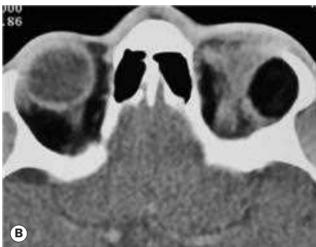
Orbital dermoid cysts – imaging. (A) Axial CT image showing a well-circumscribed heterogeneous superficial lesion; (B) deep dermoid – CT showing a well-circumscribed cystic lesion and bone remodelling (Courtesy of K Nischal – fig. A; A Pearson – fig. B)
